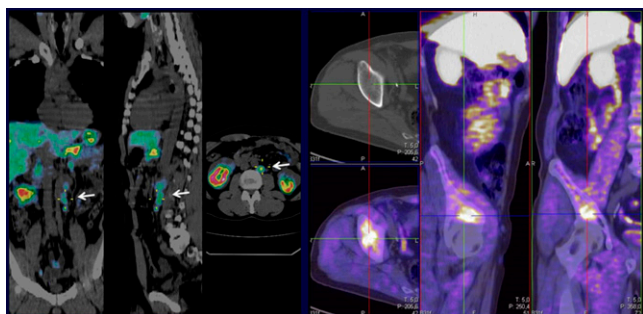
^{18}F -fluorocholine PET/CT is more likely positive with a higher Gleason score of primary tumor. Example images. Left: lumbar lymph node recurrences in a patient treated with radical prostatectomy and lymphadenectomy (Gleason score, 10; PSA = 0.24 ng/mL). Right: osteomedullary lesion in the right ischium in a patient candidate for adjuvant radiotherapy (Gleason score, 9, PSA = 0.47 ng/mL).
